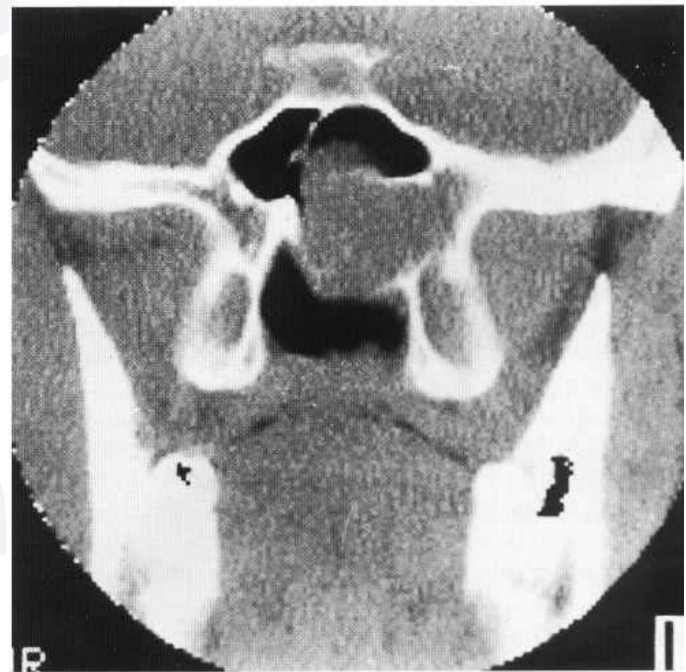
A small juvenile angiofibroma arising from and eroding the pterygoid lamina. Coronal CT scan showing the pterygoid plates.
